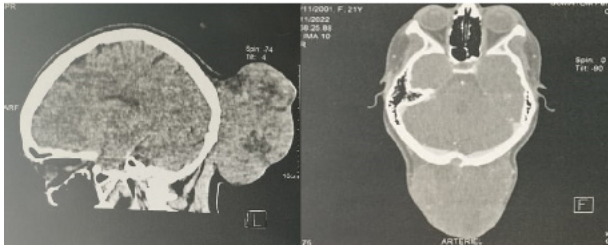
CT scan images of the tumor lesion.
